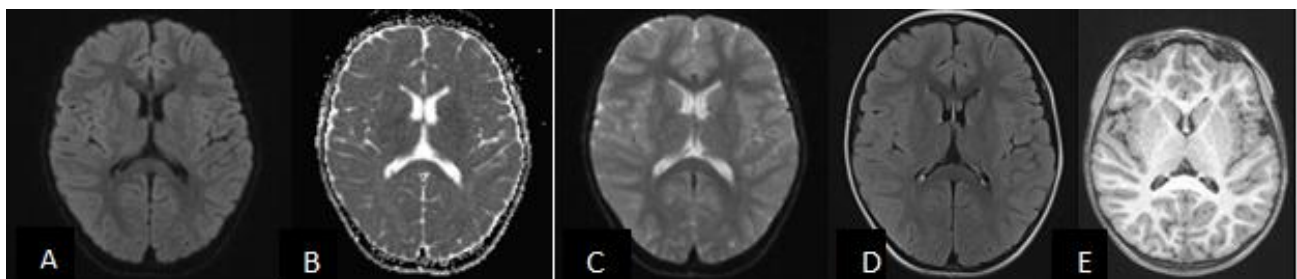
Cerebral MRI without contrast injection at D30 (A: diffusion sequence; B: ADC sequence C:T2, D: FLAIR and E: T1) showing the total regression of the splenium lesion of the corpus callosum.
